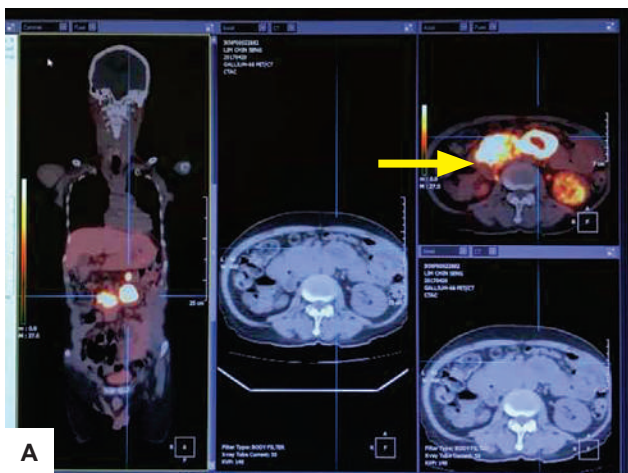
Ga-68 DOTATATE PET-CT showing uptake at 3rd part of duodenum (SUVmax 88.3), stomach (SUVmax 132) and abdominal nodes (SUVmax 69.7).
